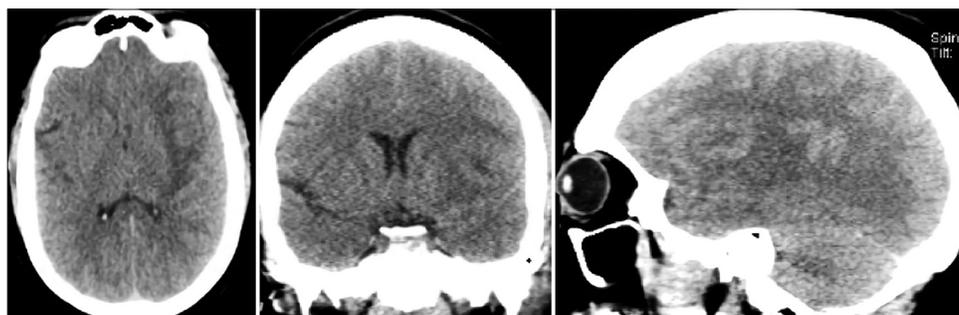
Axial (left), coronal (middle), and sagittal (right) CT scans on admission showing an area of low attenuation with a central hyperattenuating focus in the left frontal lobe causing mass effect on the frontal horn of the left lateral ventricle and rightward 2 mm midline shift.
